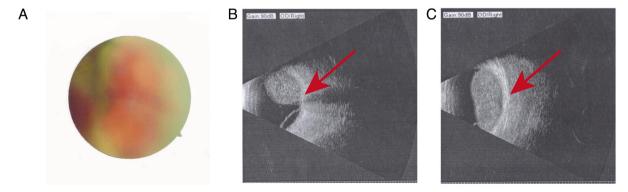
Right eye fundus photography and right eye ultrasound. (A) The right eye shows a significant elevation of the retina, with a pale colour and a well-defined margin of the optic disc, while the other structures are not clearly visible. (B and C) In the vitreous cavity, there are visible clumps of high reflectivity connected to the spherical wall, with stripes of high reflectivity below (Red arrow).
